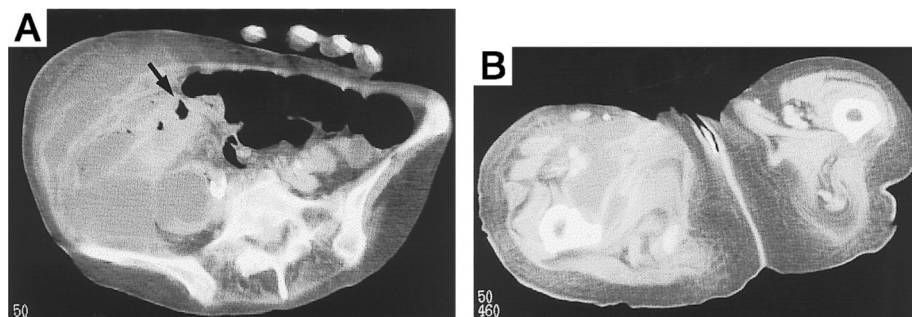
A, The computed tomography shows a large retroperitoneal, psoas and subcutaneous abscess and swelling of the ascending colon wall (arrow); B, Abscess was extended to the right thigh.
